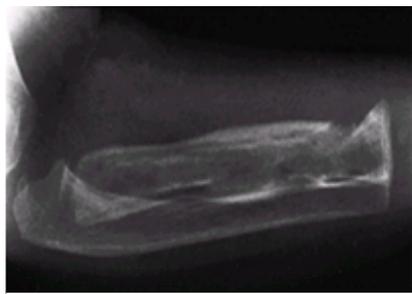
Lateral radiograph of the forearm in this infant demonstrate the typical changes of sickle cell osteomyelitis: longitudinal fissuring, diaphyseal location of the infection, and developing involucrum. These changes would be expected in any chronic infection of bone, and are not unique to sickle cell osteomyelitis.
